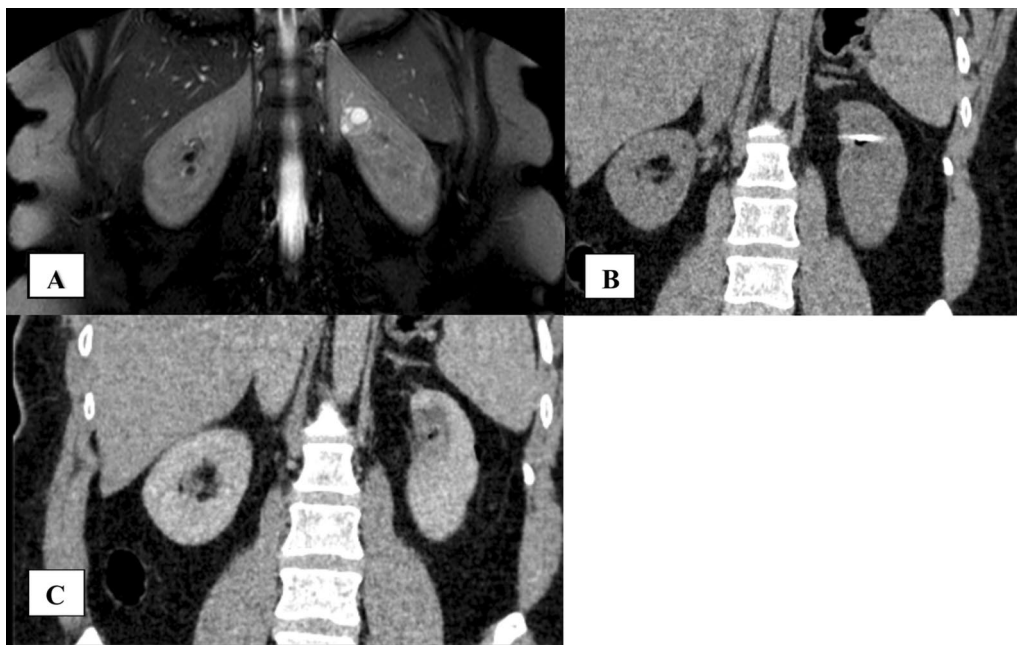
Left kidney upper pole RCC treated with MWA. A Pre-treatment MRI demonstrating the T2 hyperintense RCC. B MWA probe in situ within the mass on CT. C Post-contrast CT demonstrating technical success with no enhancement within the ablation zone and an air locule
